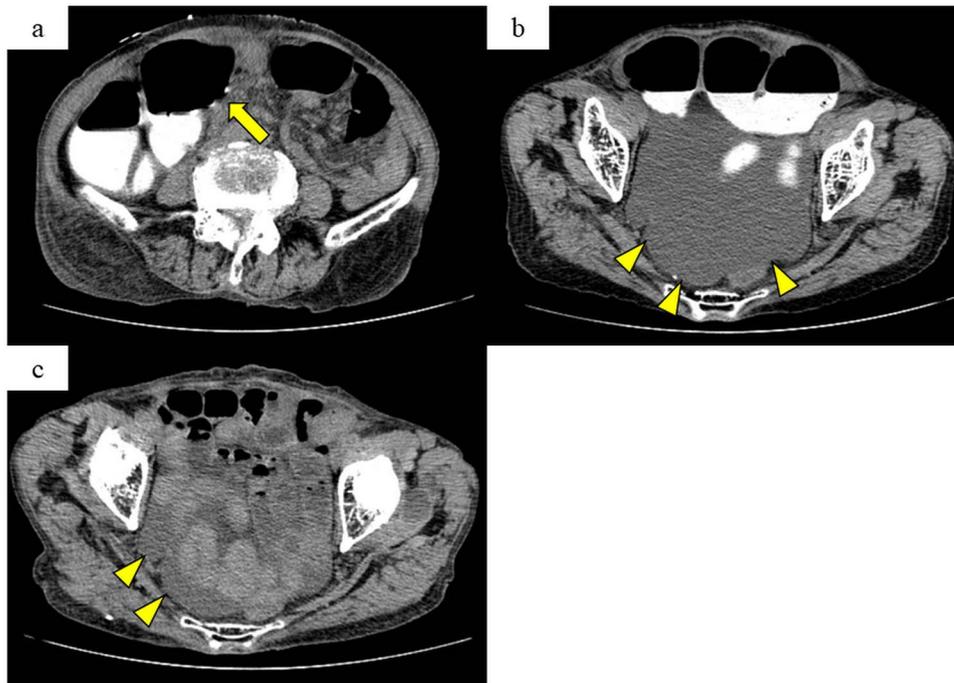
Enhanced CT. (a) and (b) Enhanced CT shows dilated transverse colon (arrow) and ascites (arrowhead) in the Douglas pouch (POD9). (c) Nine months after surgery, CT shows a small volume of ascites (arrowhead) in the pouch of Douglas.
